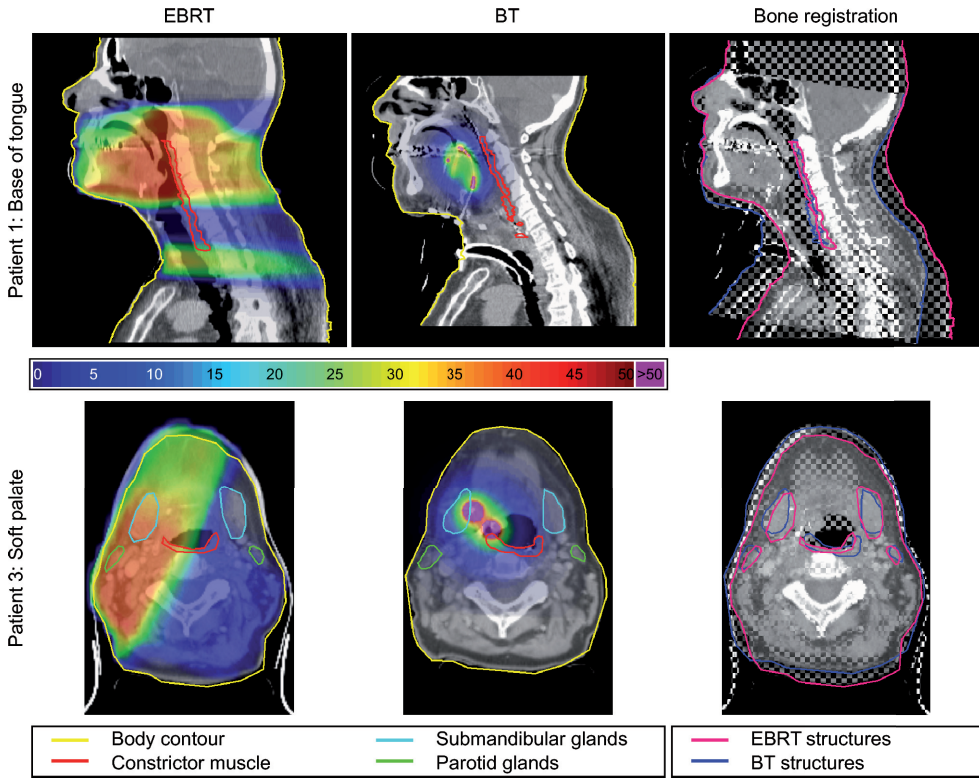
Anatomical changes between EBRT and BT for patient 1 and 3. The first row shows the sagittal planes of patient 1. Notice the large anatomical changes between the EBRT and BT CT scan, mostly caused by the neck dissection, catheter insertion and different patient positioning. The second row presents the axial planes of patient 3. The first column shows the CT scans used for EBRT planning, the second column the repeat CT scans taken after catheter implantation and just before BT and the last rigid registrations based on bone. Notice that rigid registration is not adequate to align both CT scans.
